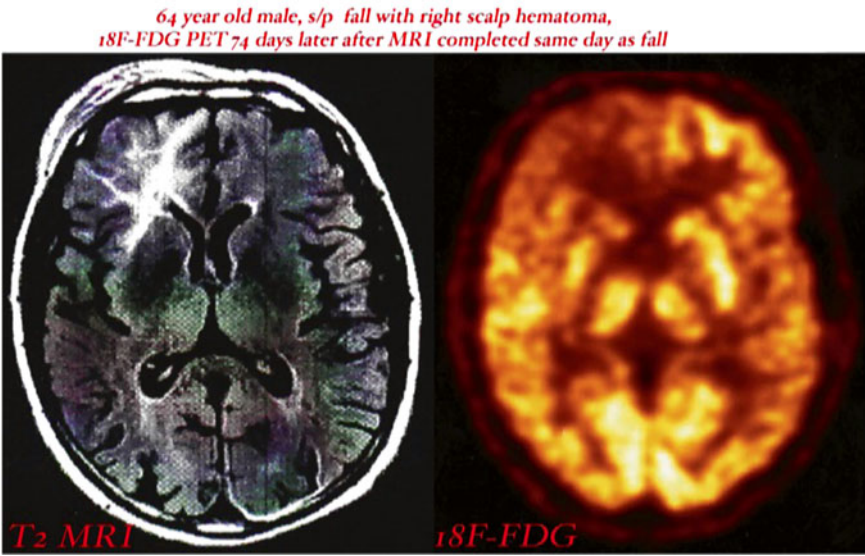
PET brain imaging is useful for identifying the functional long-term effects of head trauma, where extensive right frontal hypometabolism is noted, concordant with an area of presumed subcortical gliosis seen on MRI
